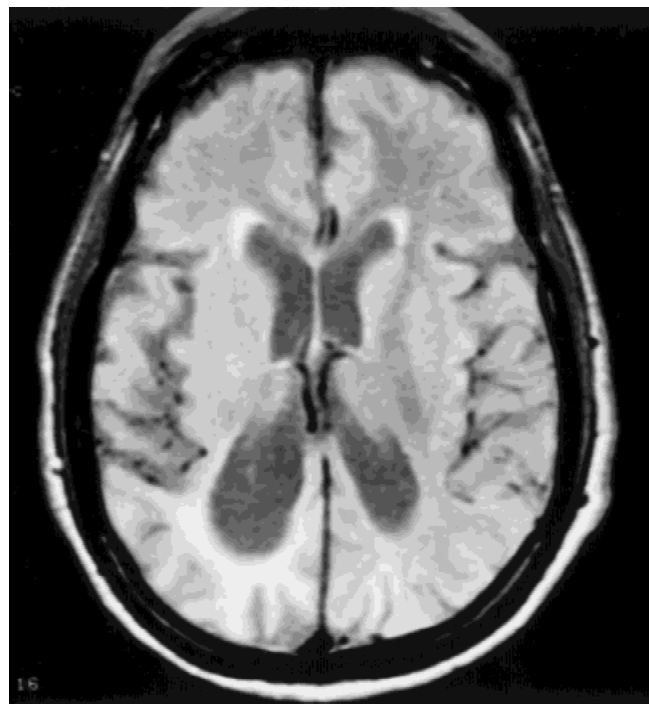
MRI of case 2 showing diffuse atrophic changes more marked in the right occipital lobe with ventricular dilatation.
